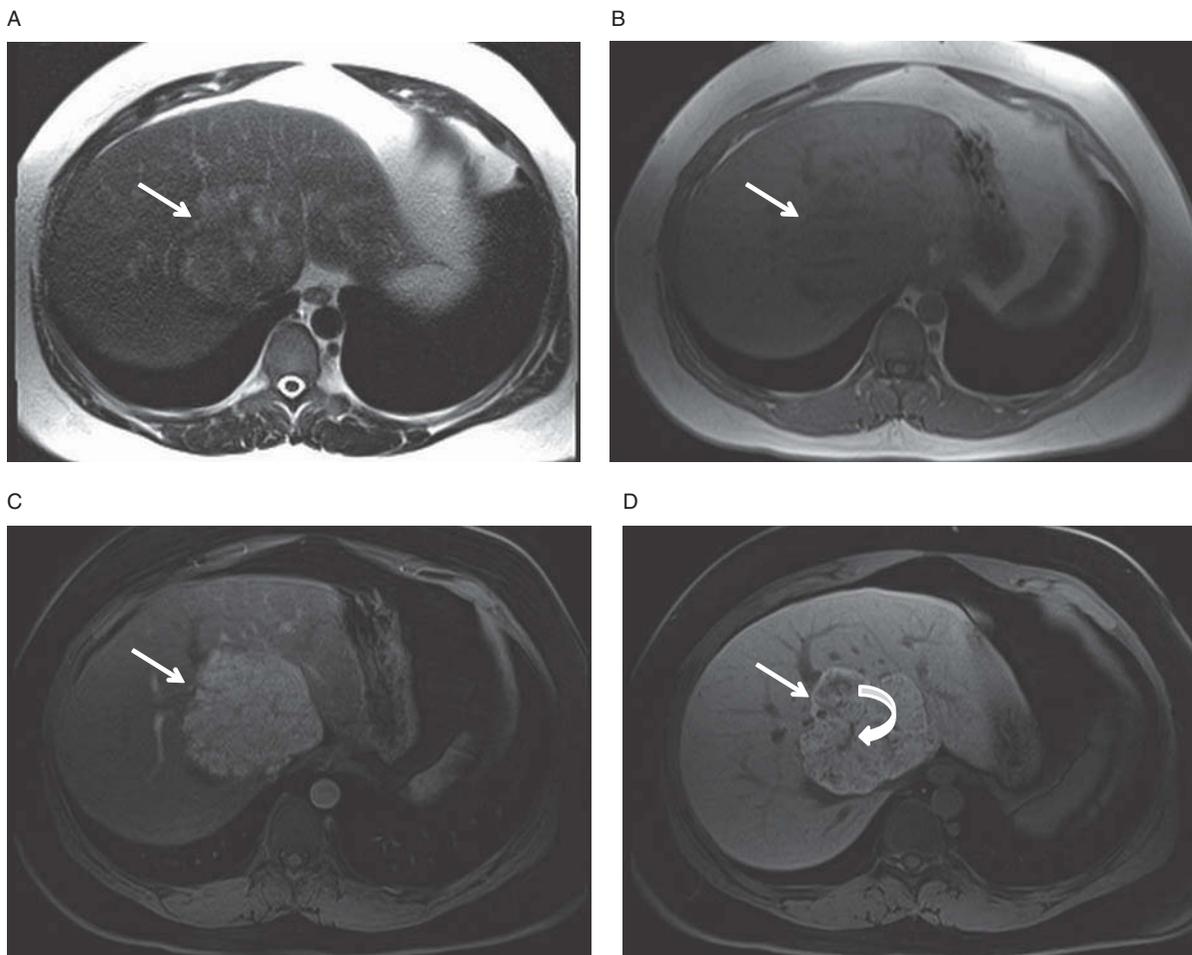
Focal nodular hyperplasia (FNH), hepatocyte-specific contrast agent gadoxetate disodium. Lesion slightly hyperintense on T2-weighted image (A), and is slightly hypointense to liver on T1-weighted image (B, arrow). The lesion enhances briskly on arterial-phase T1-weighted, fat-saturated image (C) and retains contrast material on 20-minute delayed image (D). Notice the often-discussed but rarely seen central scar (curved arrow).
